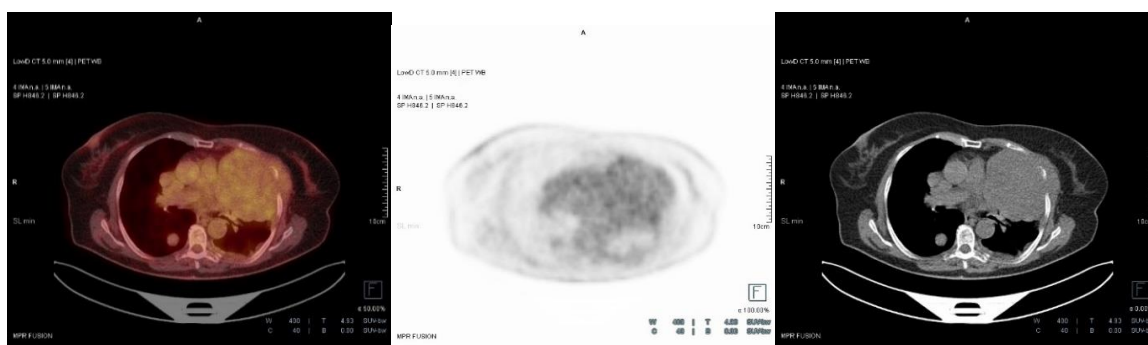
Positron emission tomography/CT using ¹⁸F-FDG. Maximum intensity projection (MIP) image shows lesions in the thorax and abdomen with mild ¹⁸F-FDG uptake
